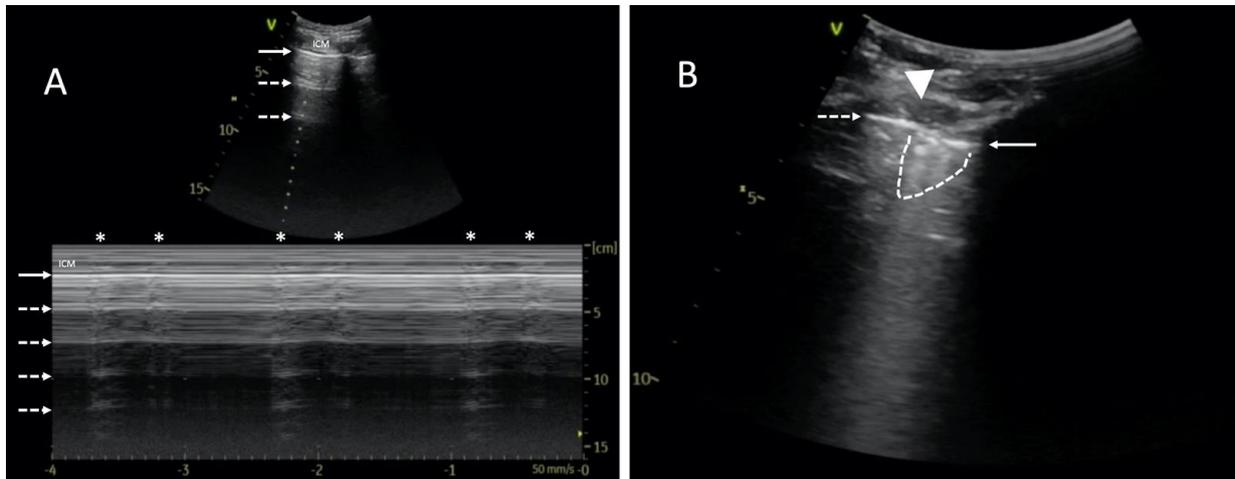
Point-of-care lung ultrasound of a 59-year-old male with severe ARDS, mechanically ventilated (Bilevel; FiO_2 60%; P_L 10 cmH $_2$ O; P_H 15 cmH $_2$ O). A left-sided pneumothorax occurred after pacemaker implantation. The study was performed using a 1.8–6 MHz convex probe. (A) Muscle contractions imitate lung pulse and hinder the diagnosis of pneumothorax. LUS examination revealed horizontal reverberation artifacts (dashed arrows). M-mode image shows a barcode sign with visible vertical artifacts (asterisks). Unlike a real lung pulse, the artifacts originate from the intercostal muscles (ICMs). Therefore, they start superficially to the pleural line and move down, passing the pleural line (solid arrow). Please see Video S1. (B) Lung point is a pathognomonic sign of pneumothorax and can be fully seen in Video S1B. This static image shows both pleural laminae separated from each other. As a result of pneumothorax, only the parietal pleura is visible on the left side (indicated with a dashed arrow). On the right side, a part of the lung with fragmented pleural line (solid arrow) and subpleural consolidation (dashed line) can be seen. The contact area is called the lung point (triangle).
